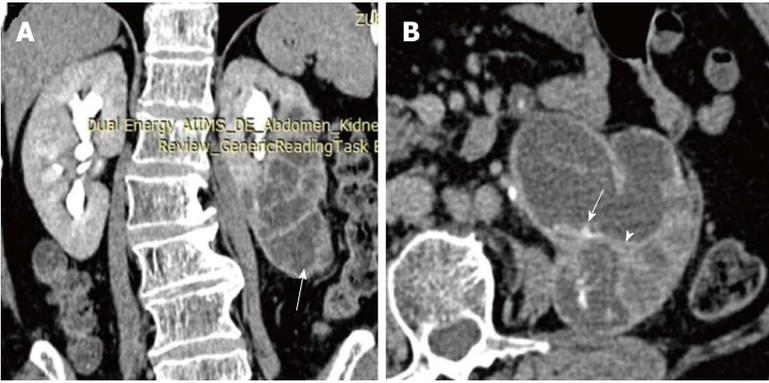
Pyonephrosis in duplex left kidney. Coronal (A) and axial (B) sections of delayed phase CECT shows left duplex kidney with obstruction and hydronephrosis of lower moiety (arrow, A). Walls of the PCS shows thickening and crescentic enhancement (arrowhead, B) suggesting pyonephrosis. PCS: Pelvicalyceal system; CECT: Contrast-enhanced computed tomography.
